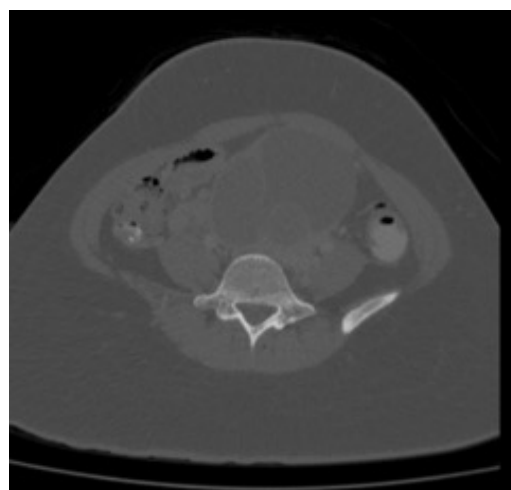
Abdomen and Pelvis computed tomography scan; There is large multiseptated cystic mass arising from the pelvic region. This cystic mass measures 10.2cm x 10.1cm x 14.3 cm (APxWxCC). It has thick enhancing wall measuring 0.8cm of maximum thickness (at inferior part). The septate also thickened and enhanced measuring approximately 2.4mm. There is no enhancing solid component within. No fatty components or calcifications. No solid papillary projection.
